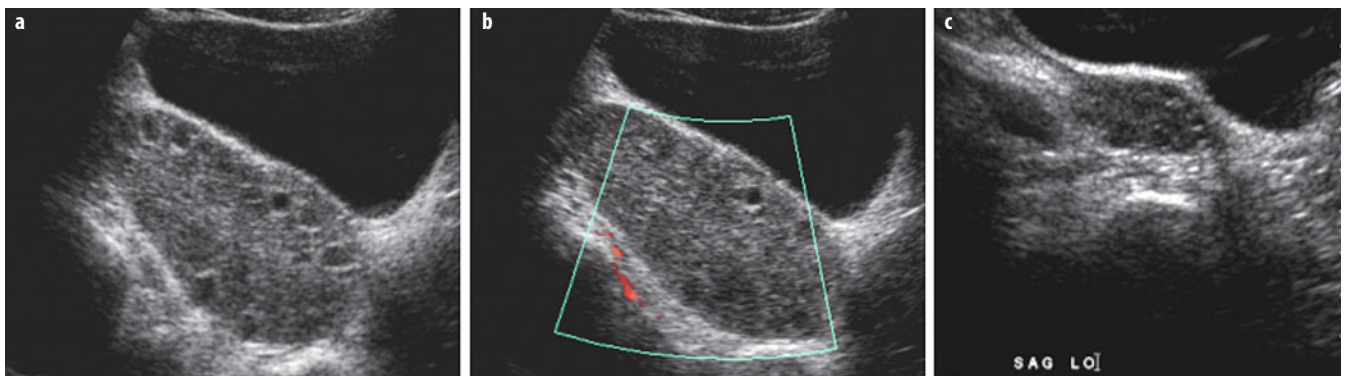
a-c. Teenage girl who presented with right lower quadrant pain. a, b Sagittal ultrasound (US) views of right lower quadrant show markedly enlarged right ovary with peripheral follicles and no internal flow, consistent with right ovarian torsion. c Comparison sagittal US view of left lower quadrant shows normal sized left ovary
